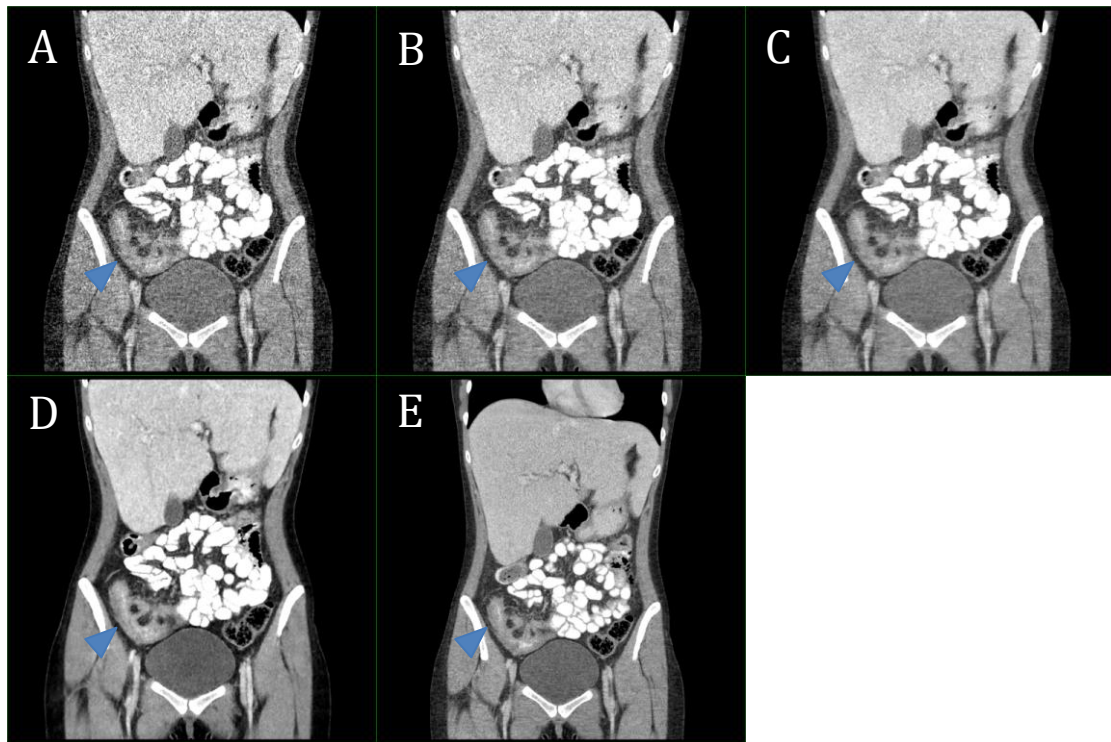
(A-E): Coronal reconstructions of modified dose CT images with FBP (A), ASiR 40% (B), ASiR 70% (C) and MBIR (D) with conventional dose CT with FBP for comparison (E). Images depict active Crohn's enteritis in the right iliac fossa (blue arrowhead) in a 26 year old lady with a BMI of 17.8kg/m^2 . The modified dose CT was acquired at 0.52mSV and the conventional dose CT at 2.3mSV .
